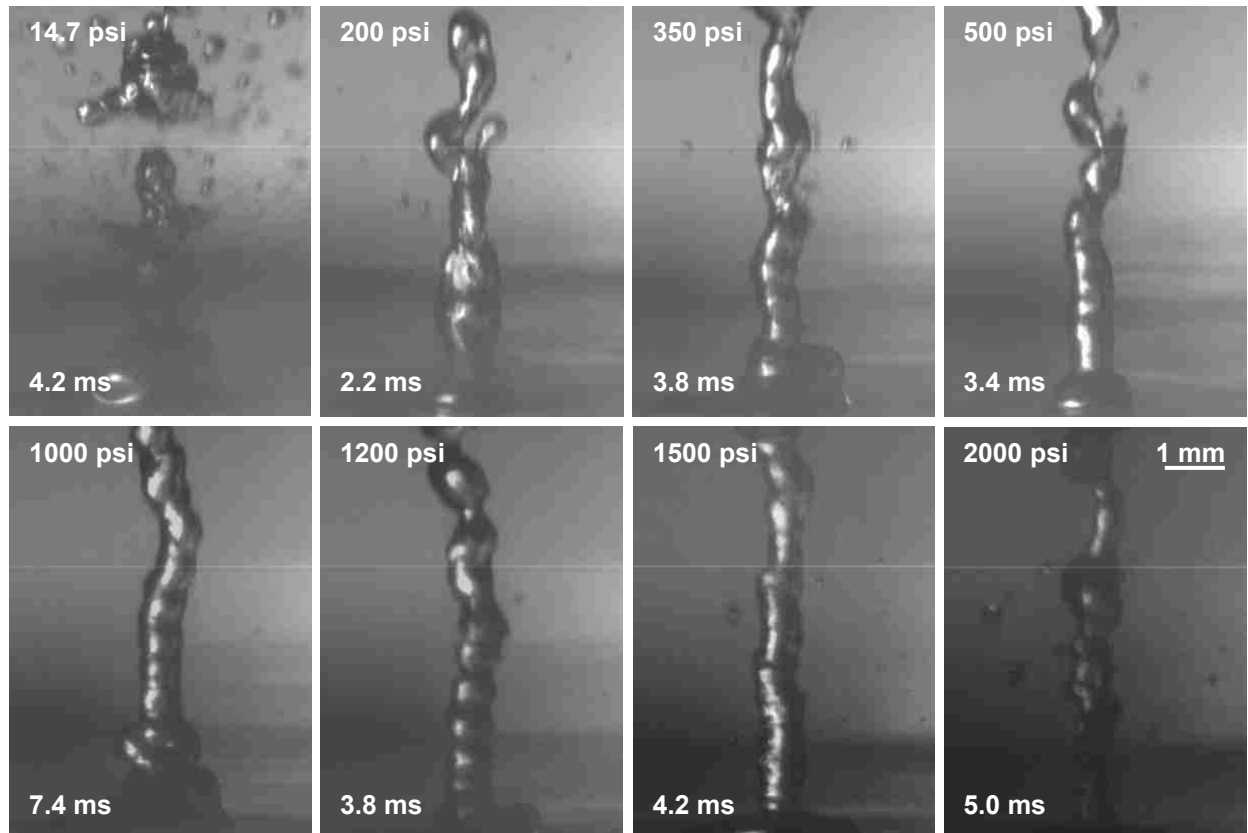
Frames from high speed videos of water atomization under high static pressure conditions when exposed to 2 MHz focused ultrasound operating at 1200 W/cm^2 ($p_+ = 6.8 \text{ MPa}$, $p_- = 5.3 \text{ MPa}$). At 14.7 psi (atmospheric pressure) atomization is very dramatic with a range of droplet diameters from 1 pixel ($\sim 20 \mu\text{m}$) to $550 \mu\text{m}$ and jet velocities reaching 11 m/s. When the static pressure is increased to 200 psi, the number of emitted droplets decreases dramatically with droplet diameters reaching $200 \mu\text{m}$ and velocities of 5-7 m/s. At overpressures of 350 psi and 500 psi, jet velocities range up to 7.5 m/s and drop diameters range from a few pixels up to $400 \mu\text{m}$. As the static pressure increases still further to 1000 psi or 1200 psi, the droplet diameters are on the order of a few pixels in diameters, with slow velocities of approximately 2 m/s. At 1500 psi and 2000 psi of overpressure, droplet diameters are again larger ($100\text{-}400 \mu\text{m}$) with jet velocities of 1-2 m/s. Exposures are 10-ms in duration and the drop chain propagates vertically at 2-3 m/s.
